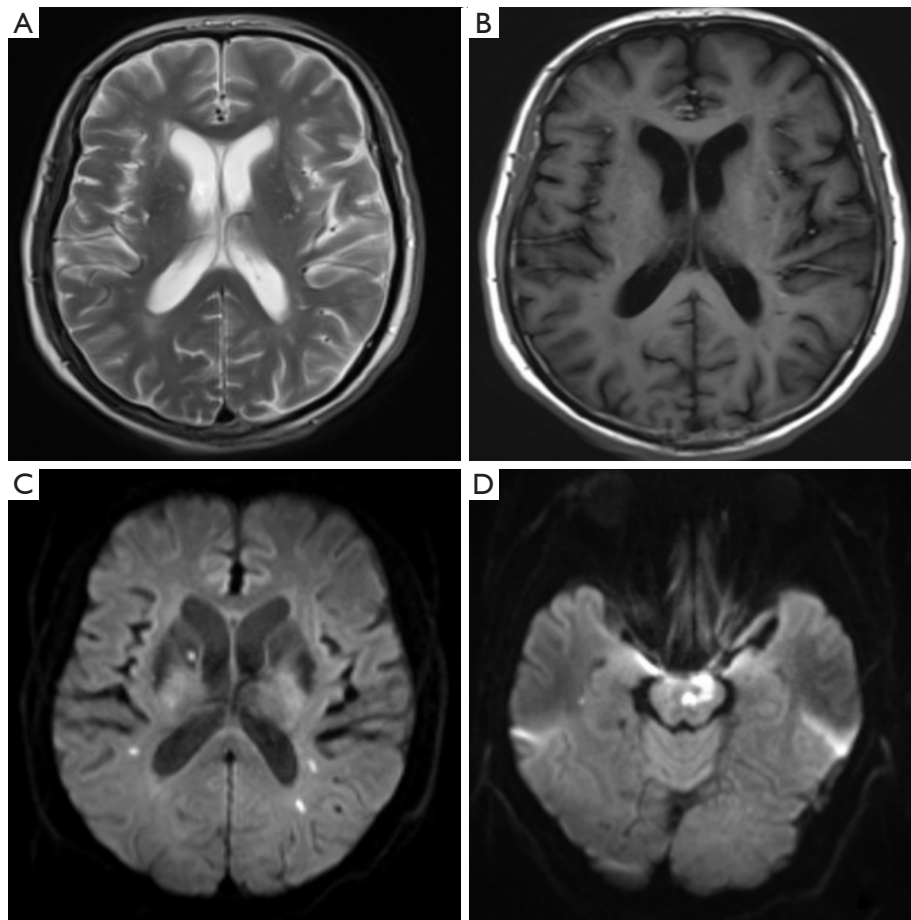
A 72-year-old male patient's head MRI on the day after admission. (A-D) Multiple lesions in the bilateral cerebral hemispheres and brain stem, low signal on T1WI, high signal on T2WI, restricted diffusion of lesions in the right basal ganglia, bilateral lateral ventricles, and brain stem on DWI. MRI, magnetic resonance imaging; T1WI, T1-weighted imaging; T2WI, T2-weighted imaging; DWI, diffusion-weighted imaging.
